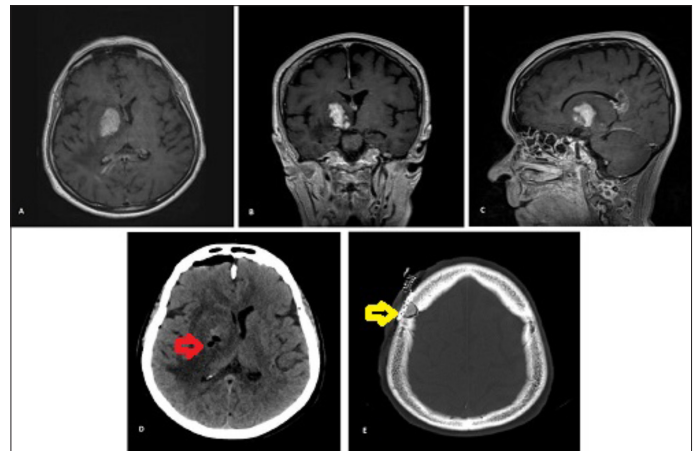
(A) Hyperintense lesion in the right basal nucleus on contrast-enhanced T1 sequence axial MRI, (B) coronal MRI, (C) sagittal MRI, (D) The area of the biopsy taken from the lesion in the postoperative early control cranial CT (red arrow), (E) Visualization of the entry point and burr hole plaque in the bone section of postoperative early control cranial CT (yellow arrow)
